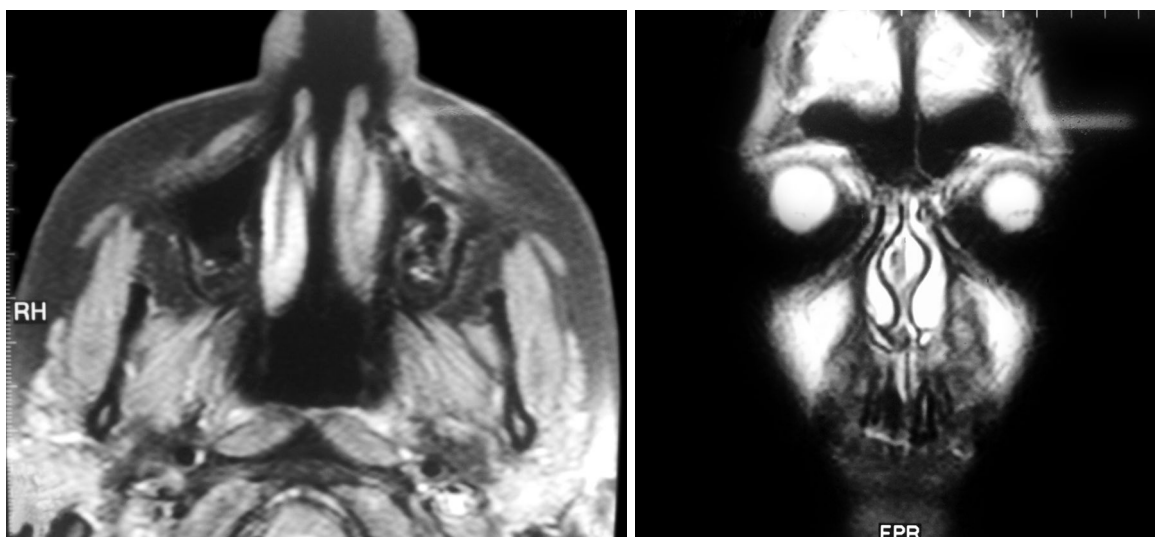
The figures showing the T₂-weighted magnetic resonance imagings of a patient in axial and coronal planes in which there is a left sided subcutaneous soft tissue swelling.
